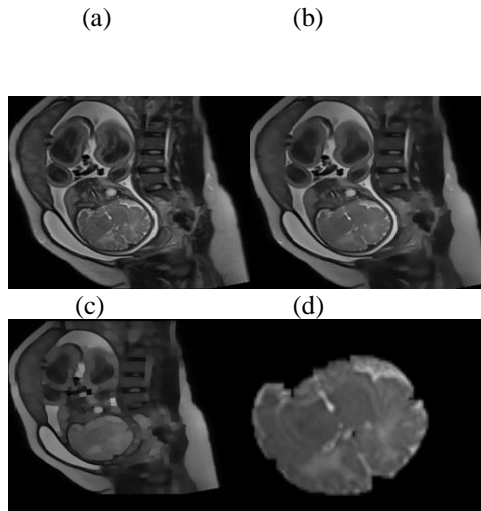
(a) Original MRI slice (b) diffused image (c) filtered image (d) segmented fetal brain
